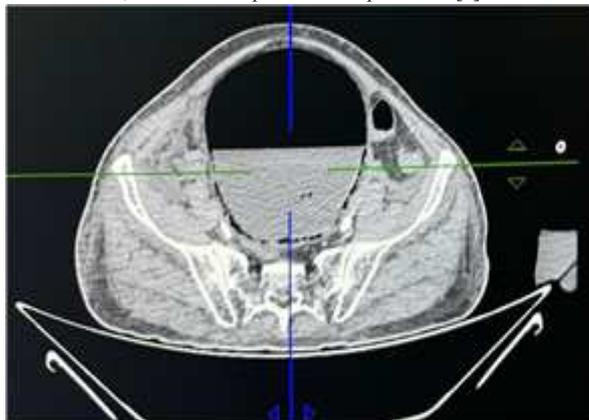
CT scan showing intraparenchymal air bubbles in the bladder wall and intraluminal gas in the bladder
